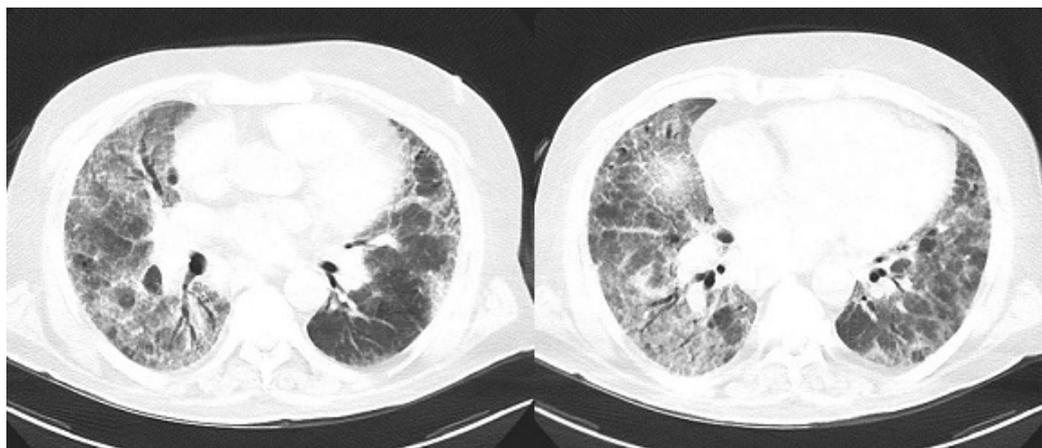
Thoracic CT revealed widespread remarkable rough reticular markings and traction bronchiectasis in parenchymal areas of both lungs. Ground-glass densities were observed which were more prominent in the middle and lower lobes.
